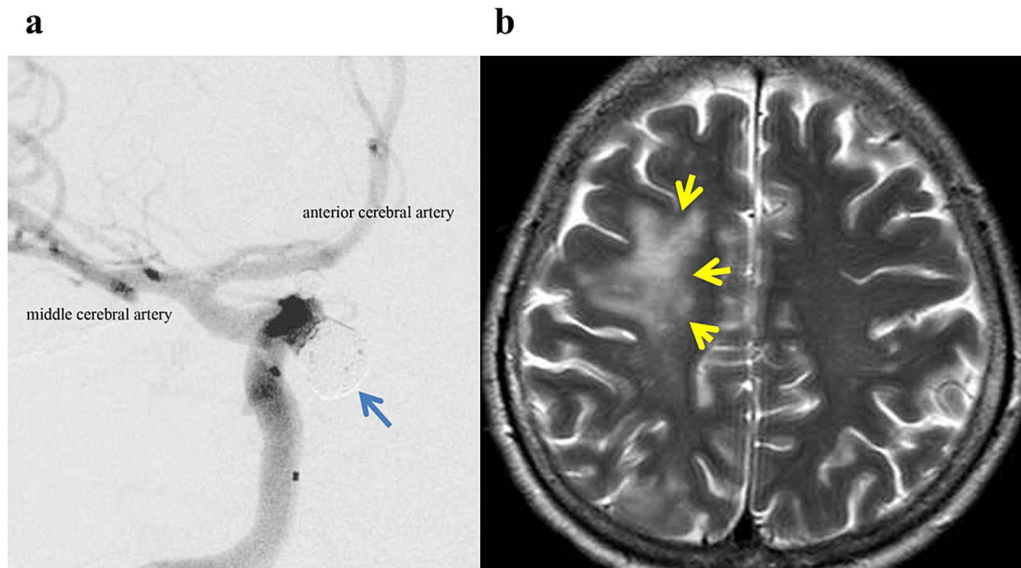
Vasculitis with metal allergy after cerebrovascular coil embolization. (a) Vascular contrast image of the right internal carotid artery. A cerebral aneurysm of 8 mm was evident in C4 of the left carotid knee (↑). The cerebral aneurysm was treated by coil embolization. (b) T2 weighted magnetic resonance image shows multiple small nodular high intensity lesions (↑) were seen at the peripheral portion of the artery with the coil.
